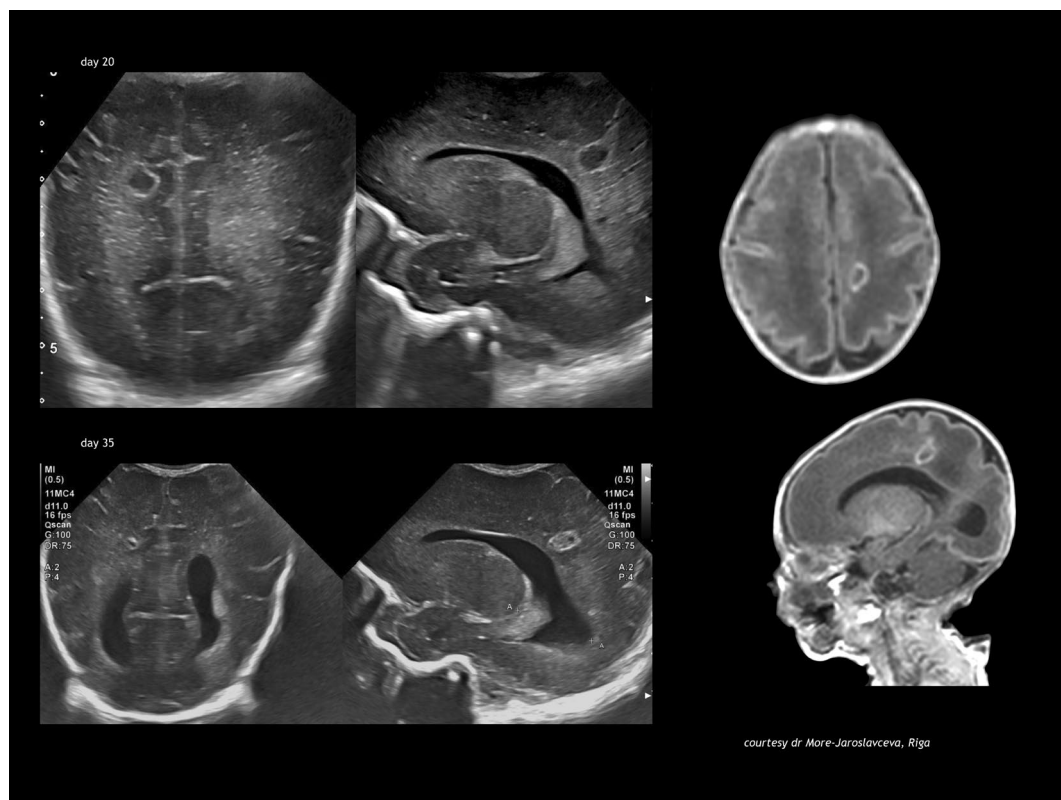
Aspergillus* focal infection. HELLP syndrome, Caesarean section at gestational age 27 weeks, birthweight 600 g, skin infection at peripheral deep line on day 13, *Aspergillus* in blood and cerebrospinal fluid day 14; cranial ultrasound showing cyst in the right frontoparietal region. Magnetic resonance imaging result of 6-week intravenous liposomal amphotericin B followed by voriconazole. Focal post-inflammatory cavity in the right parietal subcortex.
